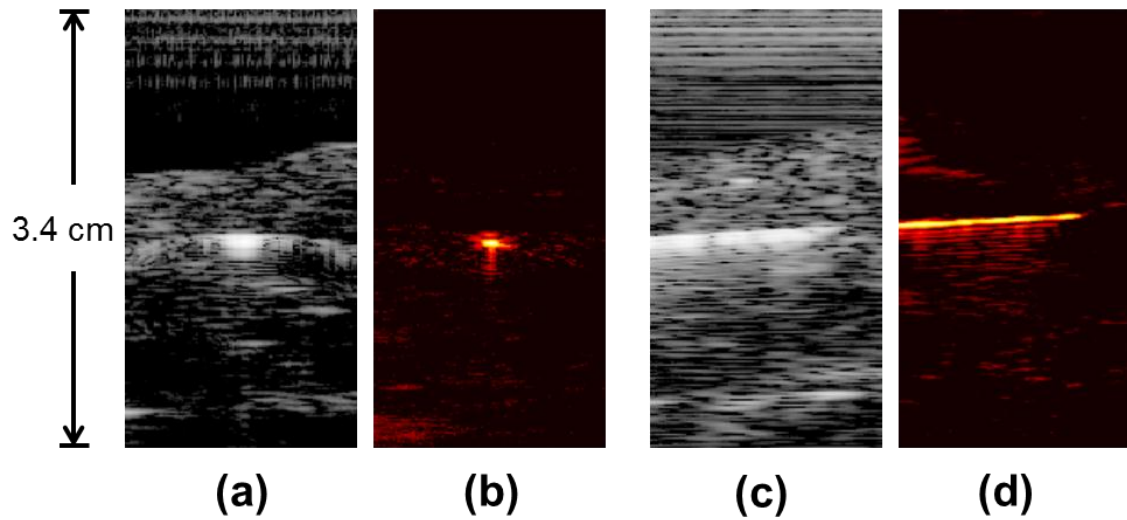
Images of hypodermic needle inserted perpendicular to ultrasound transducer. Needle is inserted horizontally through pork loin sample. Transducer is located towards the top of images. (a) Ultrasound image of needle cross-section in pork sample. (b) Photoacoustic image of needle cross section where the needle is easily visible. (c) Ultrasound image of needle and tissue in transducer imaging plane. (d) Photoacoustic image of needle in transducer imaging plane, where the metal needle is clearly visible. Dimensions of pork loin approximately $30 \times 30 \times 30 \text{ mm}^3$. Ultrasound images are displayed at 40 dB, photoacoustic images 20 dB.
